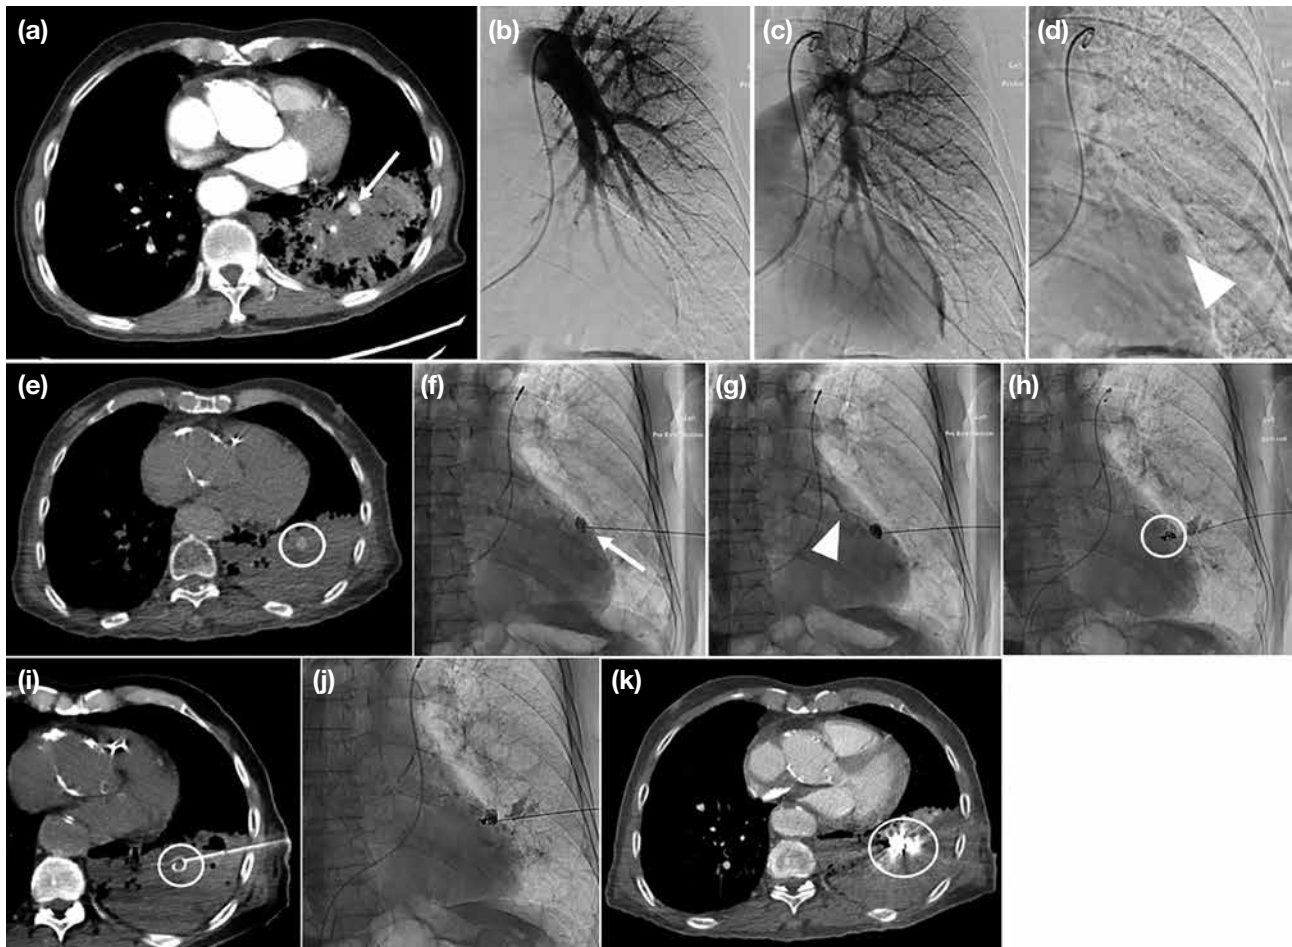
(a) An 88-year-old patient. Urgent computed tomography aortogram showing pulmonary consolidation and haemorrhage in the left lower lobe, with a 0.9-cm enhancing lesion within the consolidation (arrow). It is closely abutting the left inferior pulmonary vein, raising suspicion of a pulmonary venous pseudoaneurysm. Known Stanford type A aortic dissection was static with no mediastinal haematoma. (b, c) Left pulmonary angiogram shows no corresponding lesion in the left lower lobe in pulmonary arterial and parenchymal phases. (d, e) An enhancing nodule in the left lower lobe appeared after pulmonary arterial and parenchymal phases (arrowhead in [d]), consistent with the computed tomography (CT) findings that it originated from the left inferior pulmonary vein rather than pulmonary artery. The location was confirmed in angiography–computed tomography (circle in [e]) for embolisation planning. (f, g) Under combined fluoroscopic and CT guidance, a 20-gauge Chiba needle (Cook Medical, Bloomington [IN], US) was used to percutaneously access the pseudoaneurysm sac. Under fluoroscopy, contrast injection confirmed needle positioning with opacification of the pseudoaneurysm sac (arrow in [f]) and the outflowing pulmonary vein (arrowhead in [g]). (h, i) Two 4 mm × 10 cm embolisation coils (Concerto; Medtronic, Minneapolis [MN], US) [circle in (h)] were successfully deployed under fluoroscopy, with coil position confirmed with CT (circle in [i]). (j) Further attempt coiling of aneurysm was not successful. 0.6 mL of butyl cyanoacrylate glue (50% dilution with lipiodol) was injected under fluoroscopy for complete sac embolisation. (k) Postprocedural CT shows complete obliteration of the pseudoaneurysm by glue and coils without residual contrast opacification (circle).
